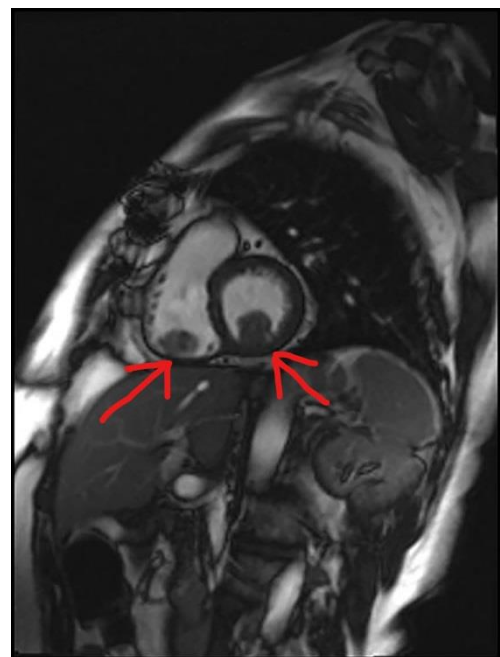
MRI showing masses in the left and right ventricle
